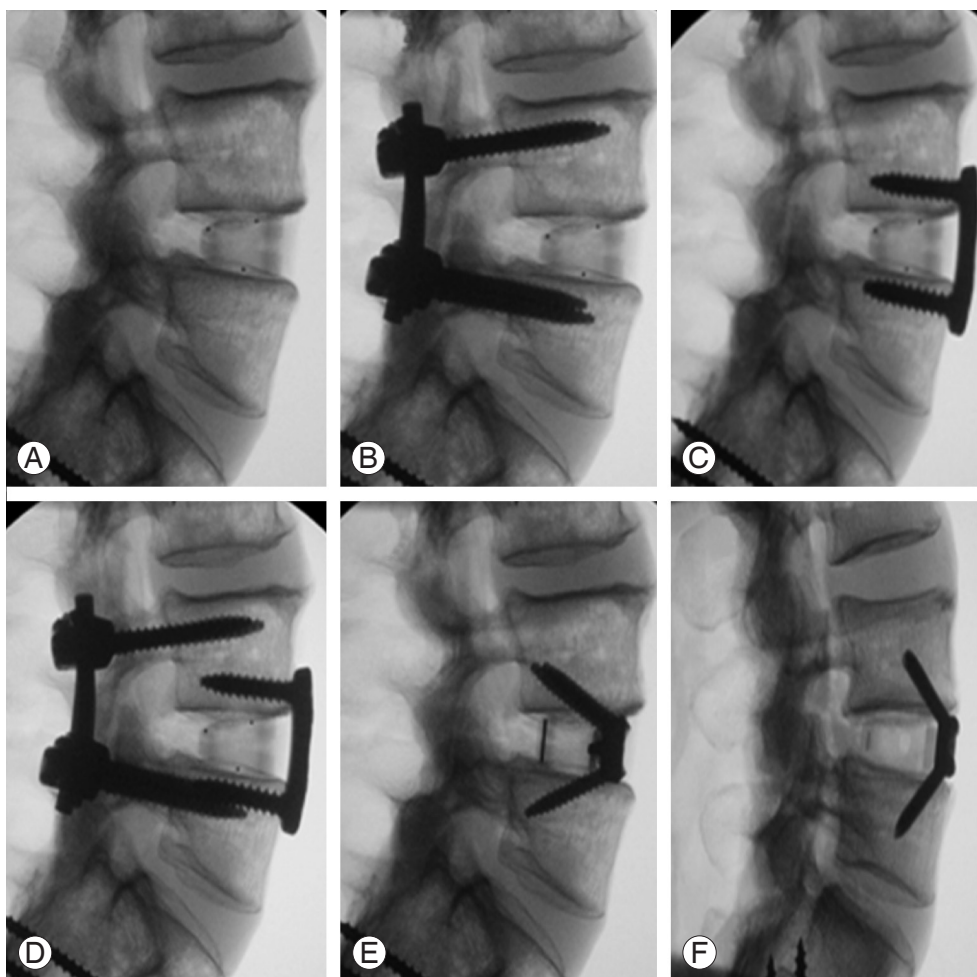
Radiographs show the following. (A) Interbody spacer. (B) Bilateral pedicle screws with spacer. (C) Anterior plate with spacer. (D) Spacer and anterior lumbar plate supplemented with bilateral pedicle screws. (E) Integrated three-screw anterior lumbar interbody fusion (ALIF) (SA3s). (F) Integrated four-screw ALIF (SA4s).
